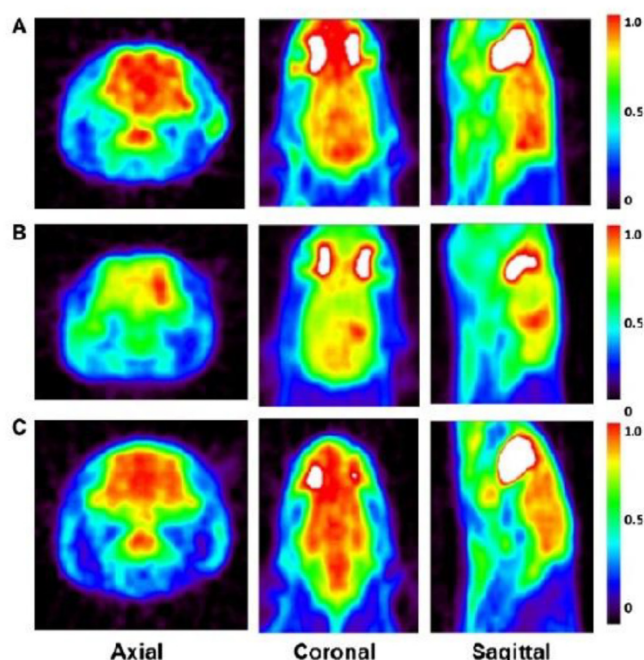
Micro PET image of average activity during dynamic scan of  $^{18}\text{F}$ -FDG.
